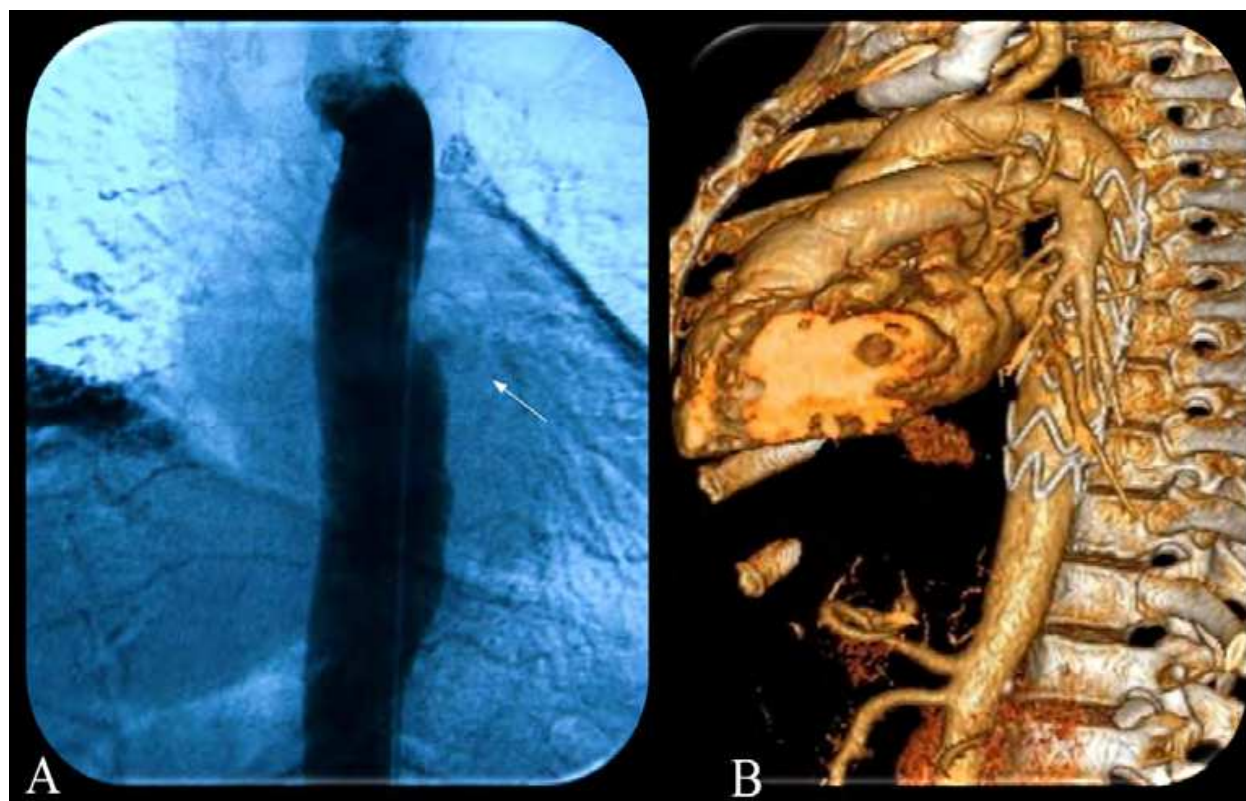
Case 22. A, Aortography showing an aortobronchial fistula (arrow) at the site of a thoracic pseudoaneurysm. B, Computed tomography scan showing accurate placement of endoprosthesis with successful exclusion of the aortobronchial fistula (B).
